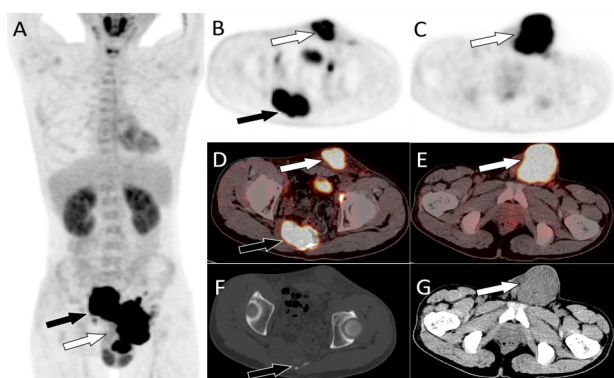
PET/CT examination of epithelioid sarcoma in the inguinal area. (A). The MIP (maximum intensity projection) figure showed a large mass of increased FDG uptake in the pelvic area, and SUVmax was 17.1 (arrows). On axial PET (B, C) and fusion images (D, E), activity enhancement was located in the coccygeal vertebra (black arrow) and left inguinal region (white arrow). Axial CT showed bone destruction in the coccygeal vertebra (F, black arrow) and soft tissue mass shadows in the left inguinal region (G, white arrow).
